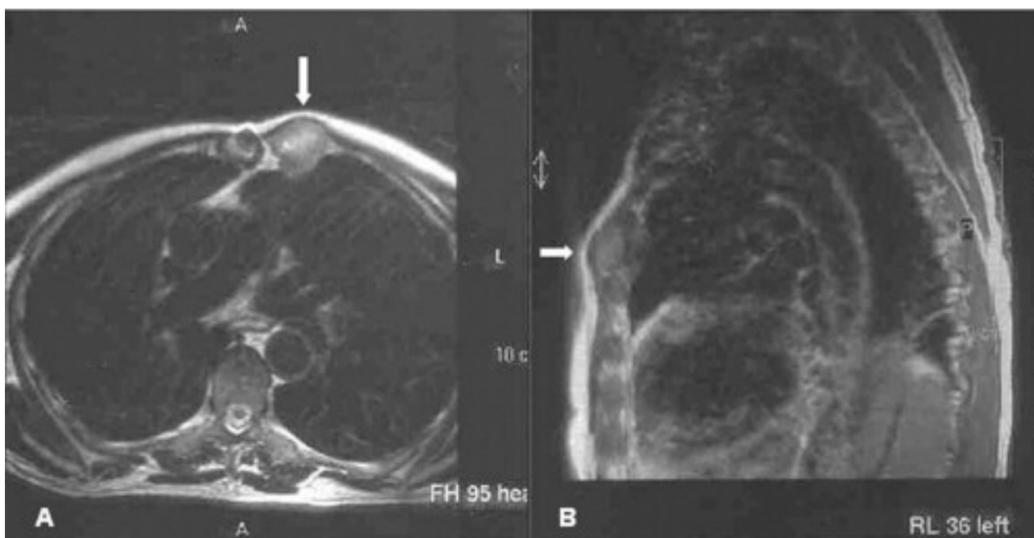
Chest wall magnetic resonance image demonstrating the recurrent tumor (A) (arrows) in cross-sectional view and (B) in sagittal view.
